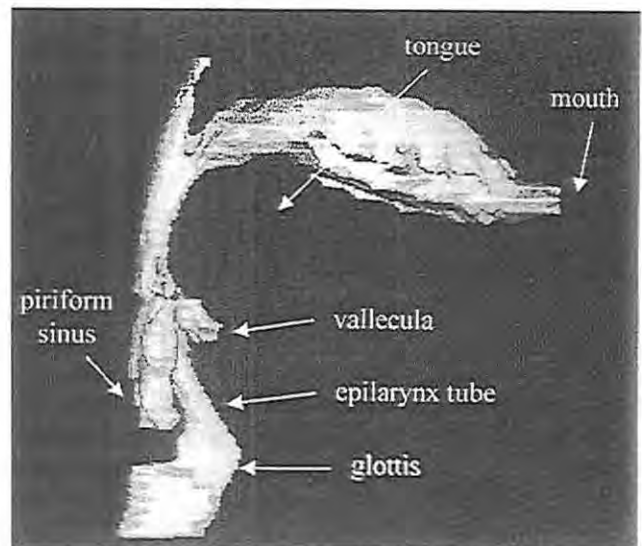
Sagittal (side) view of the human airway as obtained by electron beam computed tomography. The vowel shape is an /a/ as in "father".
